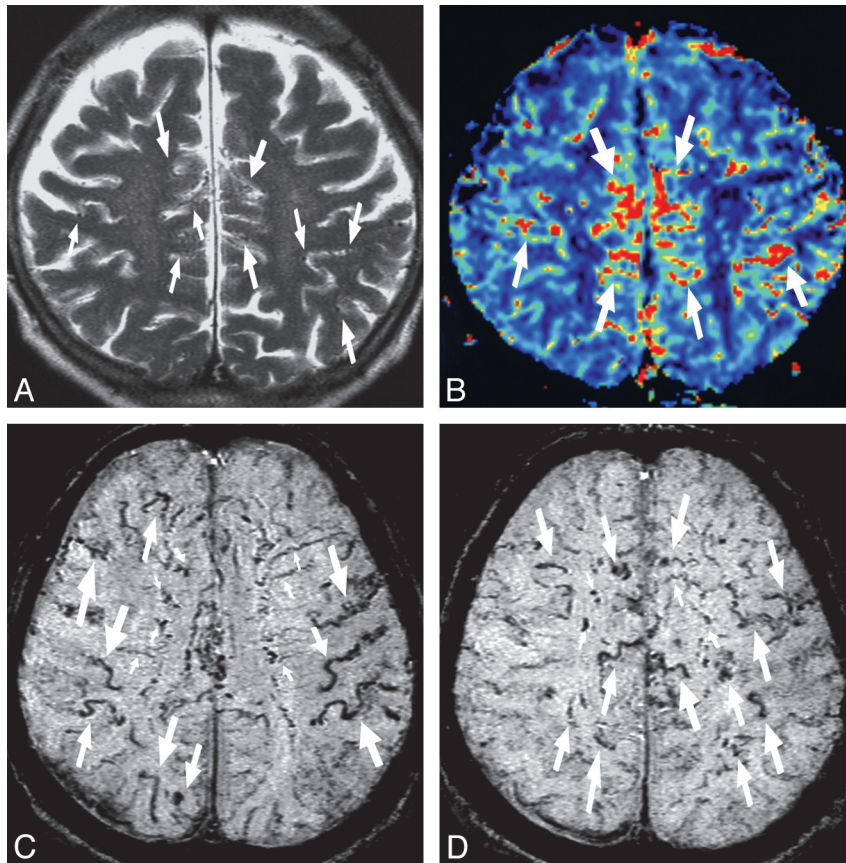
DAVF at the superior sagittal sinus with both hemispheres affected in a 77-year-old man (case 3). *A*, T2-weighted image shows multiple abnormal small flow-voids (arrows) in the interhemispheric fissures. *B*, DSC shows increased cerebral blood volume around the interhemispheric fissures and parietal sulci (arrows). *C* and *D*, SWI shows dilation of cortical (large arrows) and medullary veins (small arrows) in both hemispheres.
